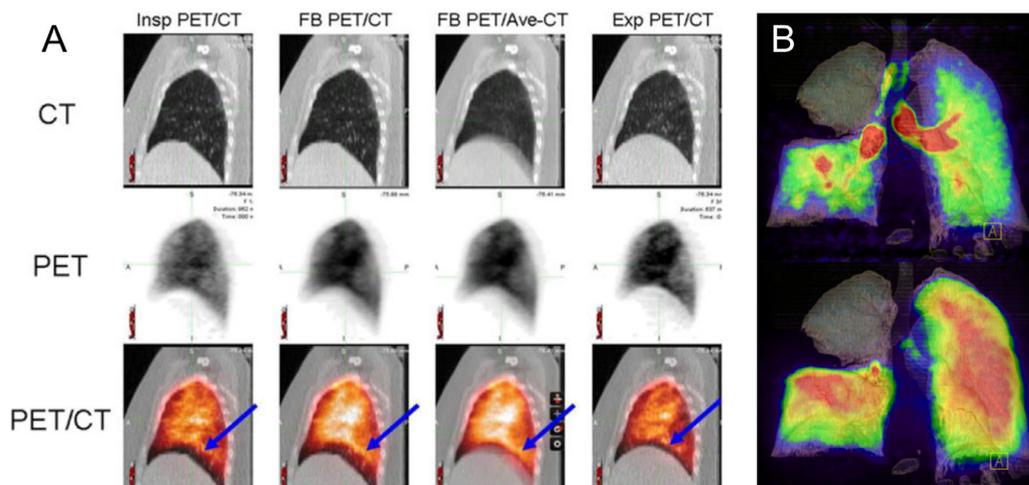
Respiratory-gated (4D) PET and CT acquisition enabling phase-matched attenuation correction. (A) Perfusion PET/CT showing effects of respiratory motion on image coregistration around the lung bases in (1) inspiratory-phase PET/CT, (2) free-breathing (FB) PET/CT, (3) FB PET / 4D CT average (Ave-Ct), and (4) expiratory-phase PET/CT. The best result is achieved with expiratory phase bin. (B) Volume-rendered PET/CT images showing large areas of aerated lung in the right upper lobe with no evident ventilation (top) or perfusion (bottom). Precise coregistration of PET and CT datasets is provided with respiratory gated acquisition. Modified with permission from Callahan et al.³⁰
